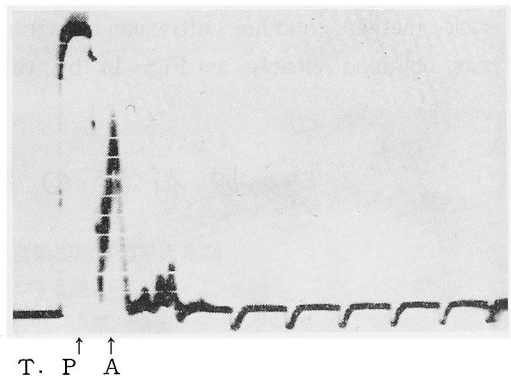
Ultrasono-echogram of Prostatic Stone.
